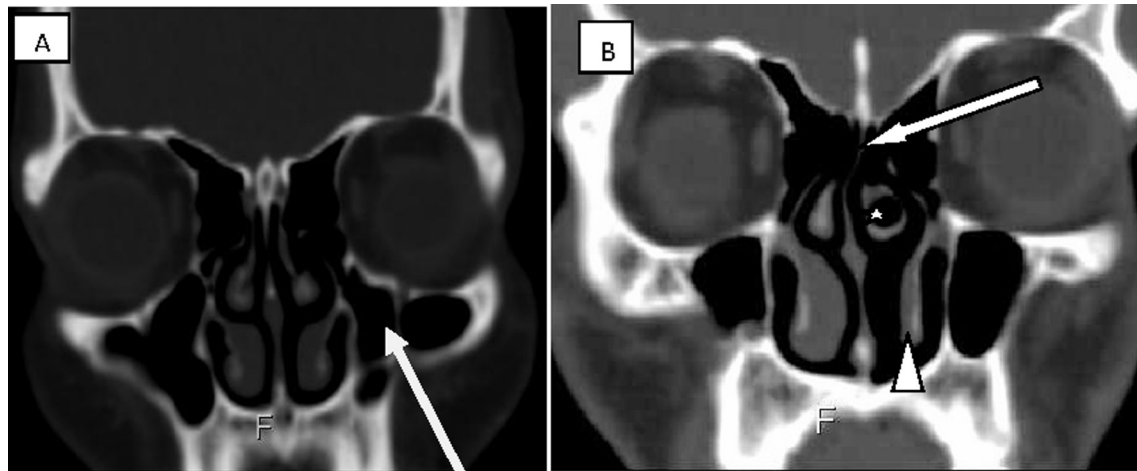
Coronal CT images showing (A) multiple septations in the left maxillary sinus (arrow), (B) pneumatized left middle conchae (white star), hypoplastic left inferior conchae (arrow head), deviated nasal septum (long arrow).
